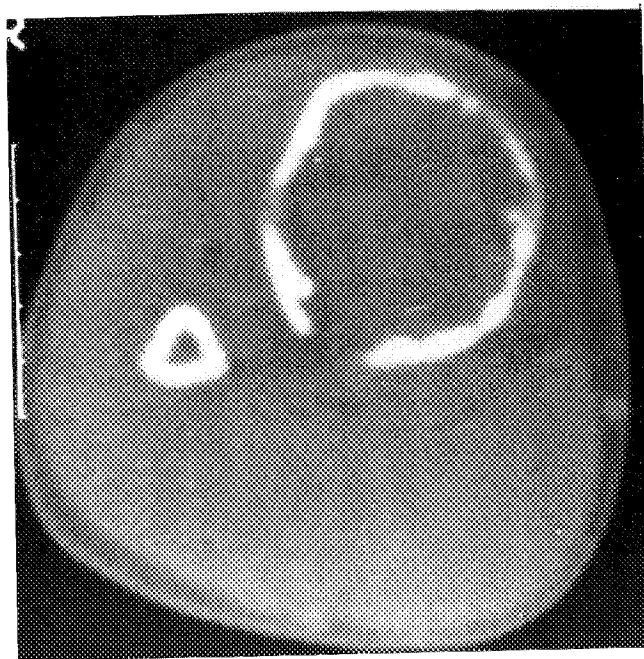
A large moderately trabeculated LGIOS, involving the metaphysis of the tibia, with cortical destruction and indistinct margins. Anteroposterior view and computed tomographic scan showed breakthrough to the cortex. Magnetic resonance imaging depicted breakdown of the cortex and intraosseous extension. All mounts confirmed the radiologic staging study (Patient 4).
